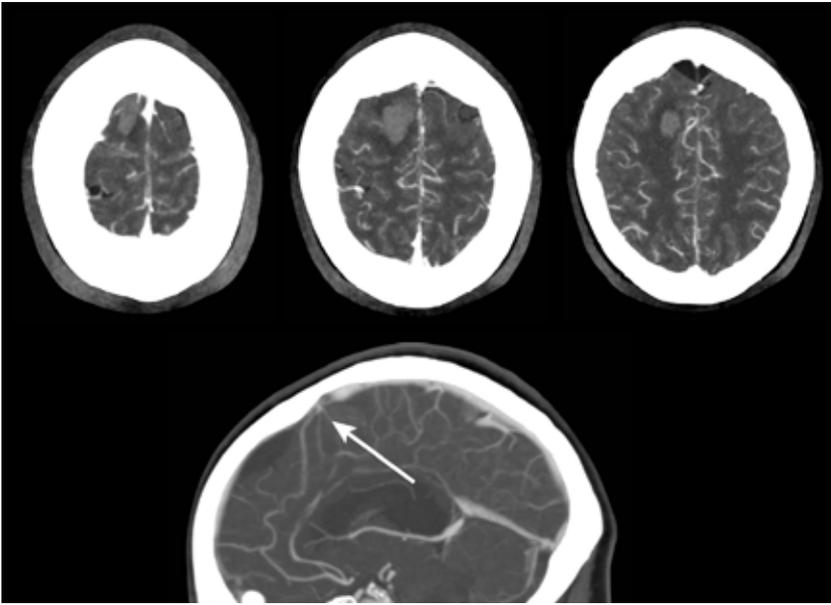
Maximum intensity projection images in axial and sagittal planes from the CT angiogram. The sagittal view showed an anterior cerebral artery branch medial to the haematoma (white arrow), but this was not enlarged, no abnormal draining vein was visible, and (as a static image) no shunt was appreciated, so a firm diagnosis of an arteriovenous malformation could not be made
